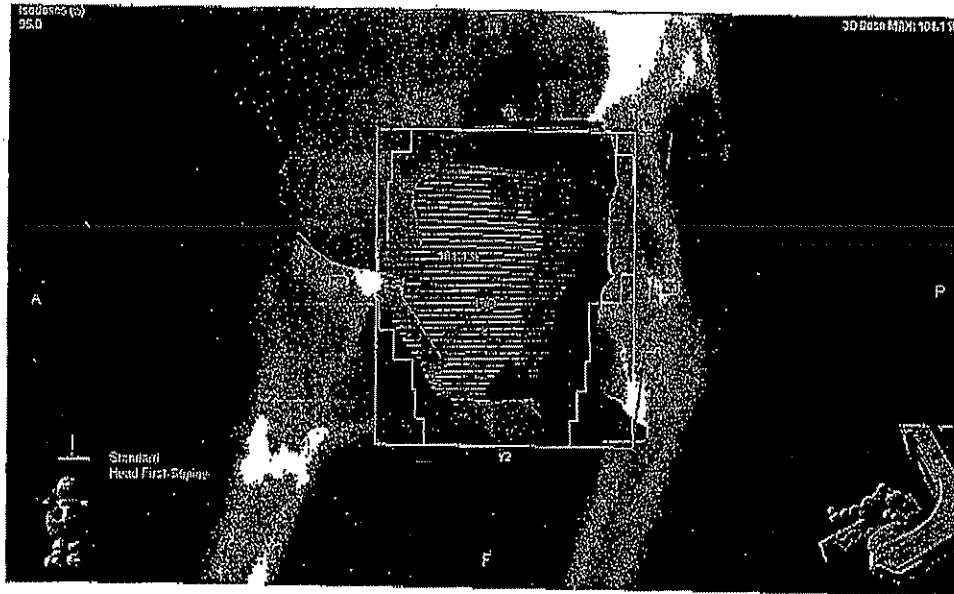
3DTPS beam's eye view display used to identify the best gantry, collimator and couch angles at which to irradiate target and avoid irradiating adjacent critical structures. Critical structures and target volumes outlined on patient's CT sections and outline of multileaf collimator aperture are shown (Varian Eclipse TPS).
